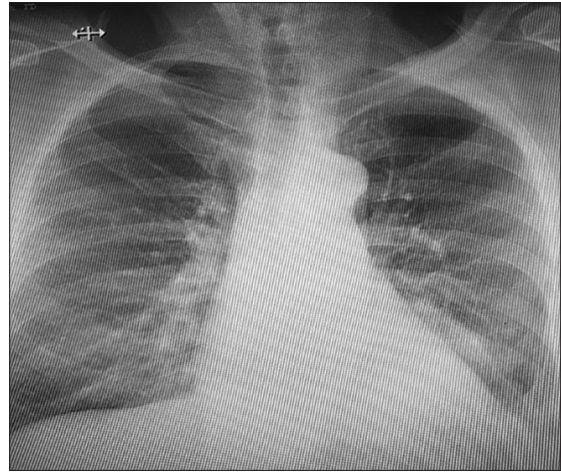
Chest X-ray revealing the remission of the left apical-subclavicular mass but a persisting left basal mass
